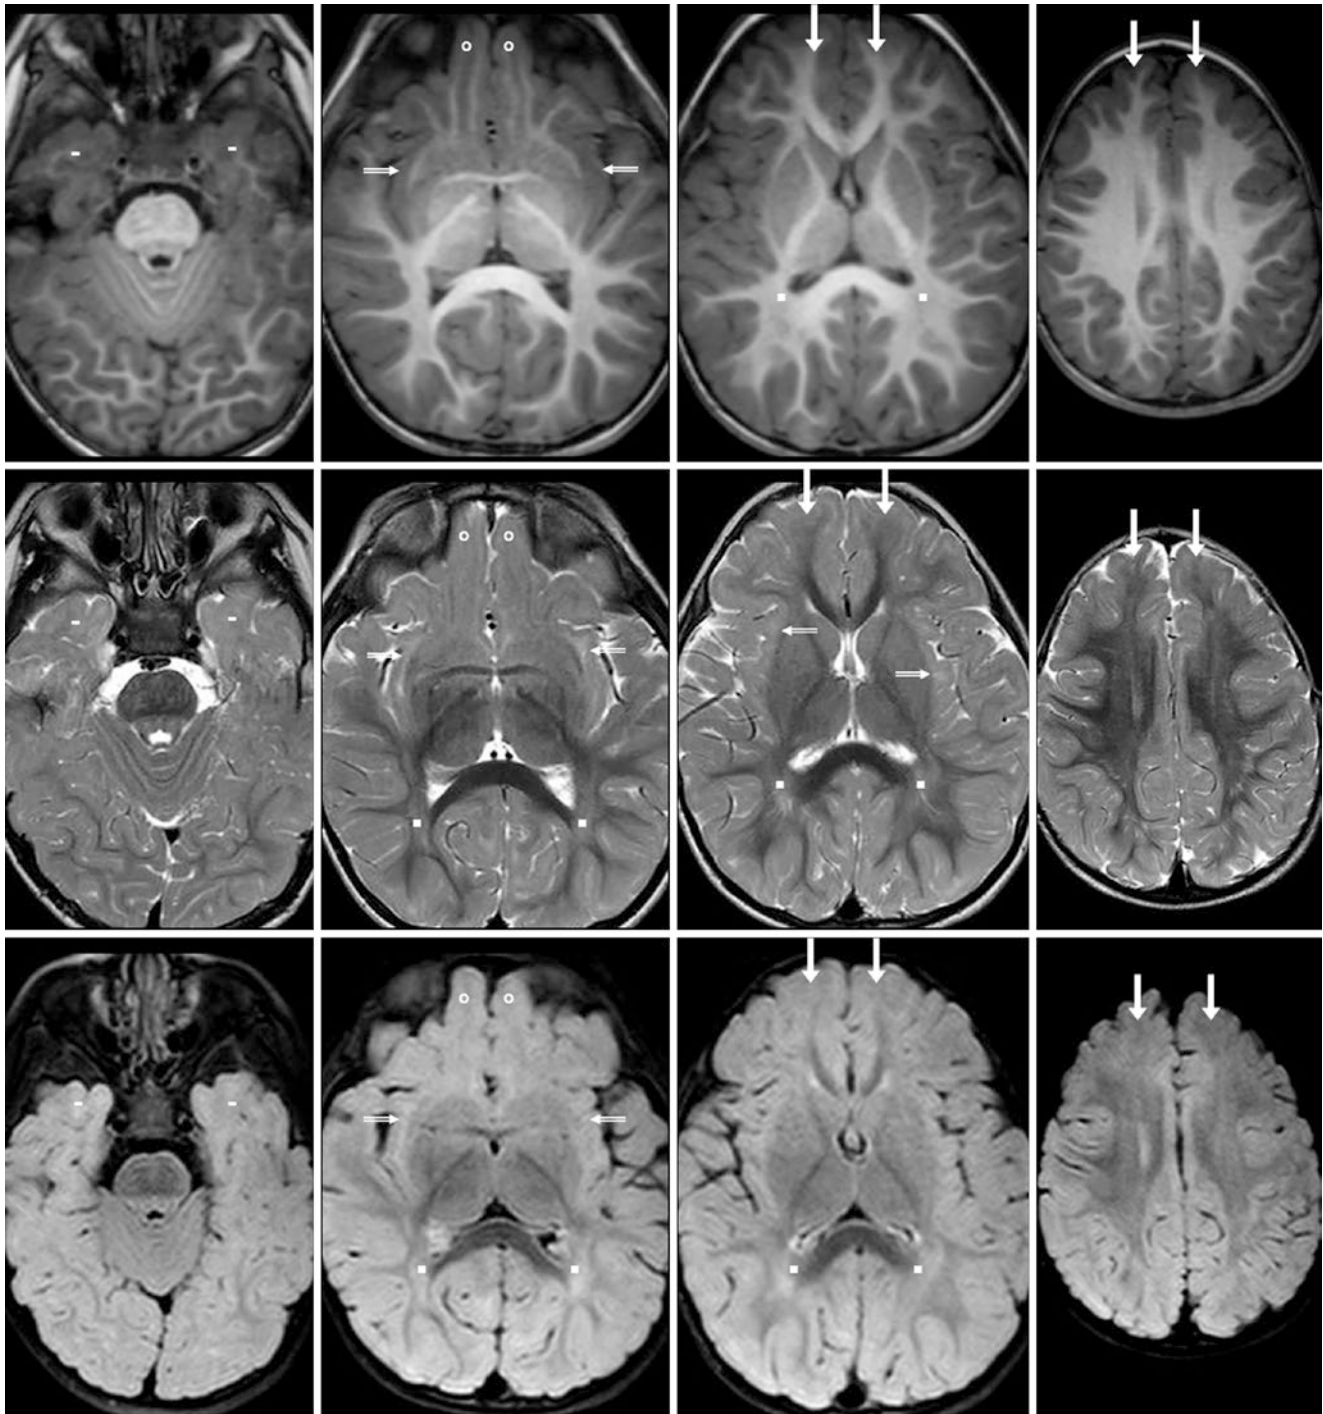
An 18-month-old with “spells” had a normal 3T MRI. On these images, note the periatrinal terminal zones (*squares*), OFWM (*circles*), ATWM (*dashes*), and the SIWM (*beveled arrows*). The appearance is nearly that of an adult. *Top row*: On GE T1WIs, the myelination appearance is nearly that of an adult, with the exception of subtle hypointensity within the SIWM and ATWM. The dorsal brainstem is slightly hypointense on this sequence. *Second row*: On SE T2WIs, the PVWM
